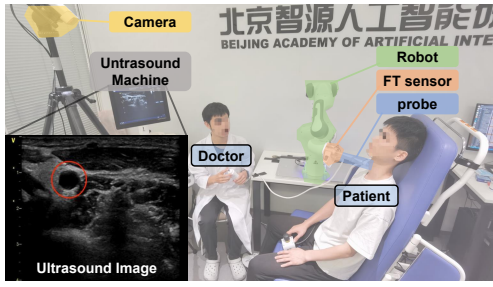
The experimental setup: (a) The hardware system consists of an ultrasound machine, an RGBD camera, a manipulator, an FT sensor, an ultrasound probe, and PCs; (b) An ultrasound image, where the red circle indicates the position of the cross-section carotid artery
